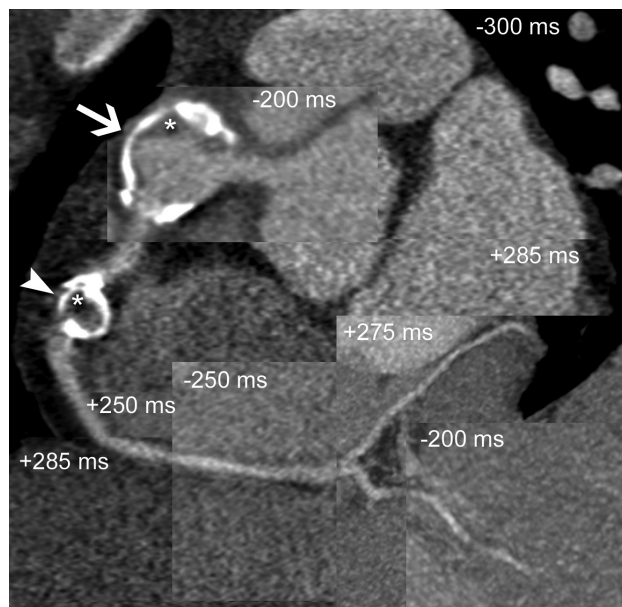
'Panoramic' multiplanar CT view of the RCA obtained by combination of datasets from different phases of the cardiac cycle. A giant calcified aneurysm is seen proximally (arrow). A second calcified aneurysm is localized in the mid-tract of the RCA (arrowhead). Hypodense material consistent with thrombus is visible in both aneurysms (asterisks). The lumen is, however, patent.
